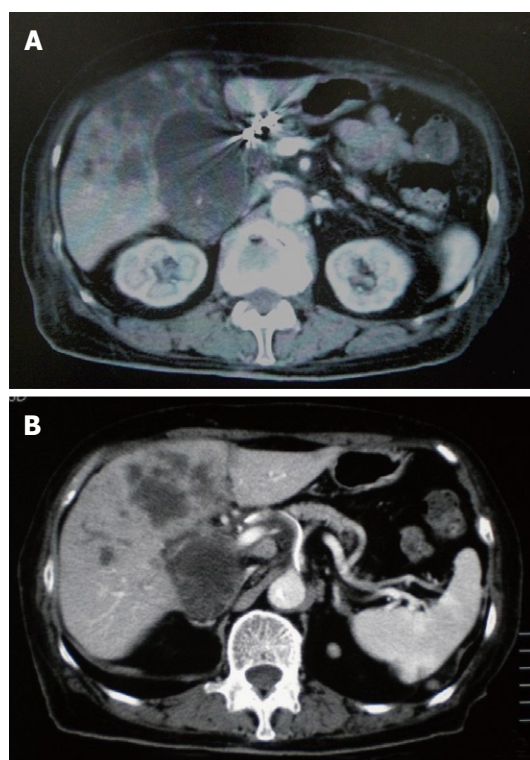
CE-CT after the end of 3 cycles of HAI chemotherapy showed a decrease in the size of tumor. A: The GB tumor; B: Liver tumor.
